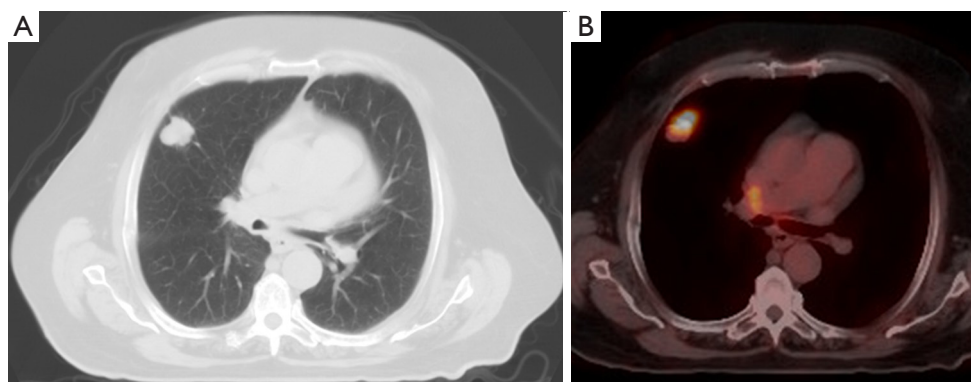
A 74-year-old man found to have a pulmonary nodule at chest radiograph (not shown). Axial CT image (A) shows a nodule in the right upper lobe with indistinct margins. Fused axial images from ^{18}F -FDG PET/CT (B) show marked FDG uptake within this lesion, highly suspicious for carcinoma. The lesion ultimately underwent biopsy, confirming lung adenocarcinoma.
